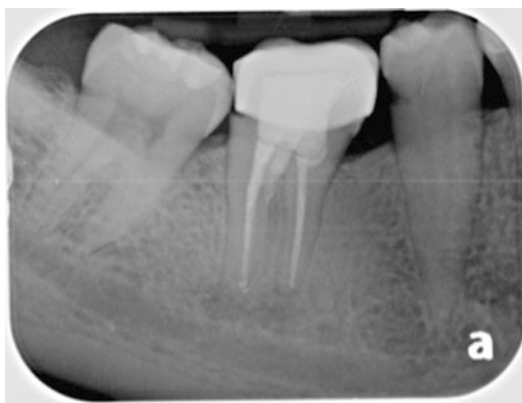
Endodontic treatment on young permanent teeth with possible open apices are good referrals to your specialist (Radiographs by Dr. Jade Rivera)
